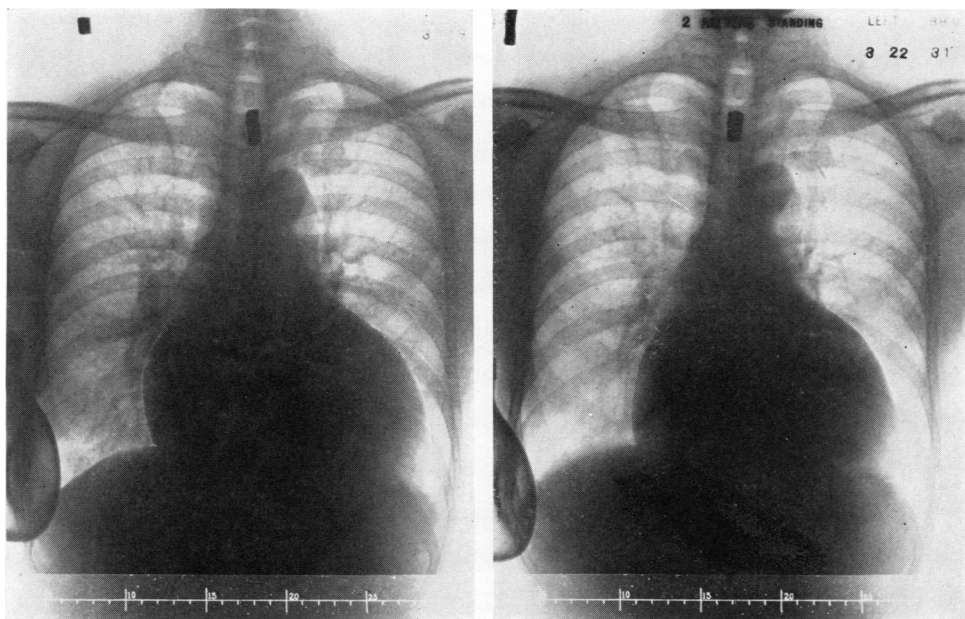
IN THIS FIGURE ARE REPRODUCED X-RAY PHOTOGRAPHS OBTAINED IN THE CASE OF D. T. T. (CASE 1)
